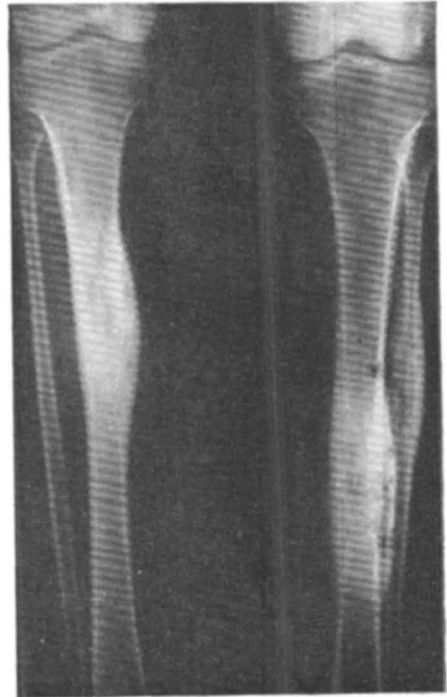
X-ray showing marked sclerosis with relatively few areas of destruction in both tibiae and left fibula. There is an abrupt change to normal bone at the ends of the lesions.
